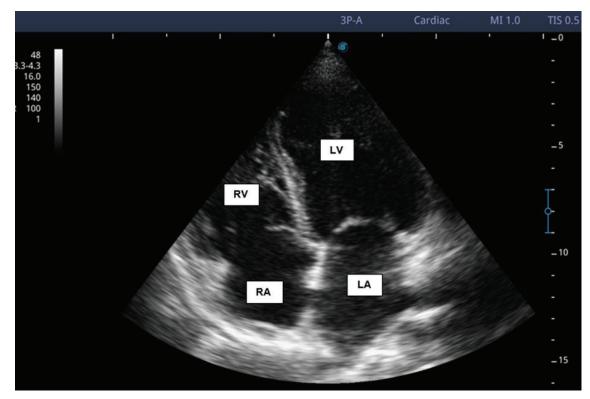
Apical 4-chamber view demonstrating the RV, RA, LV, and LA
